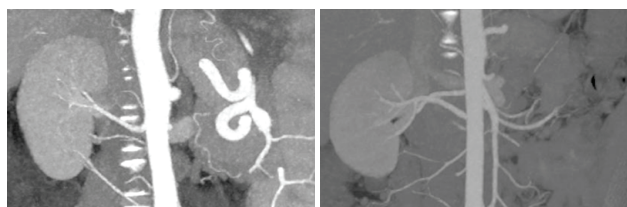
Curved coronal reformatted CT images showing (a) Left hilar accessory artery (b) Left polar artery (c) Right polar artery and (d) Right hilar artery
